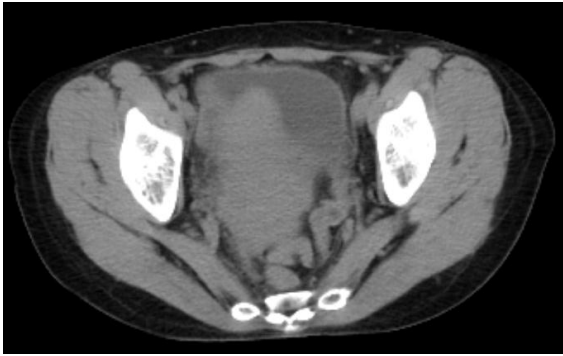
Computed tomography of the patient B. 1962, patient with cervical cancer before radiation therapy: a sharp hypertrophy of the supravaginal part of the cervix, deformation of the bladder, which is attached to the cervix throughout; the iliac lymph nodes are visualized.
